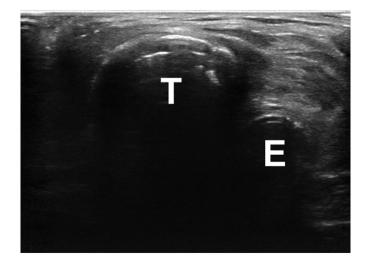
Sonographic appearance of an esophageal intubation. T = Trachea; E = Esophagus.
